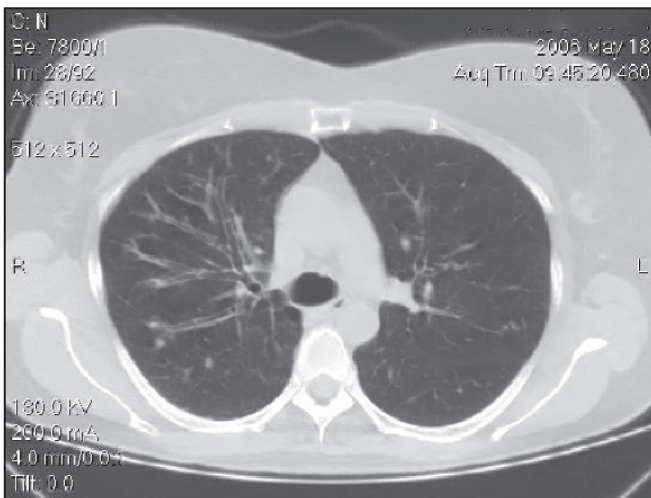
Axial computed tomogram of the chest in patient 1 showing tubular bronchiectasis with nodularity in the right upper lung zone.
